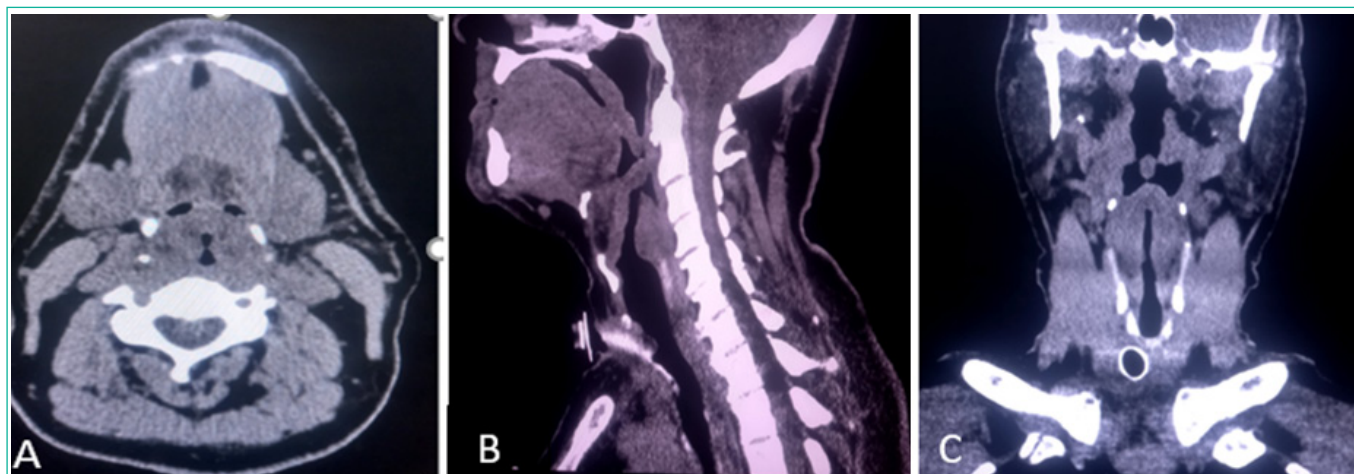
Cervical CT scan, sagittal section (A) coronal section (B) and frontal section (C), showing homogeneous thickening of the epiglottis and the rest of the supraglottic region, with well-defined, regular contours.
